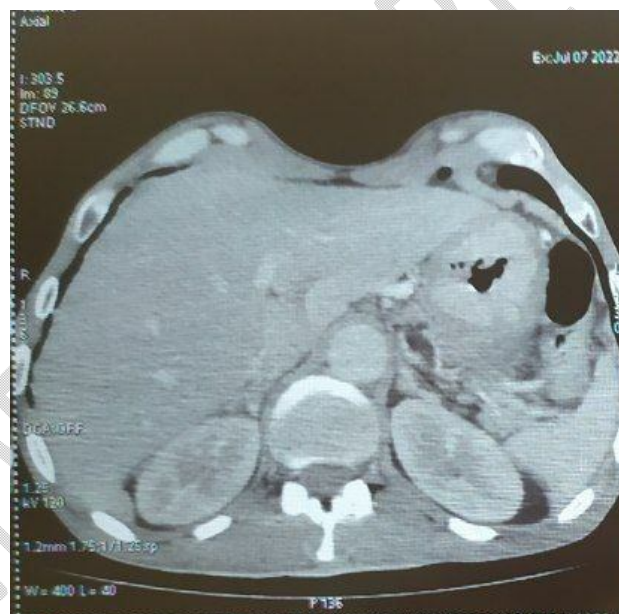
Axial slides of abdominal CT scan a pneumoperitoneum
